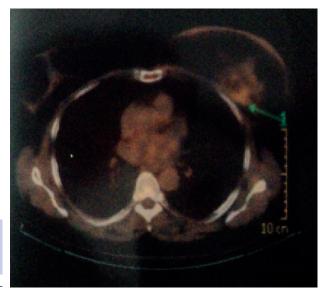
Limited area with high intense FDG PET metabolism on the chest wall
